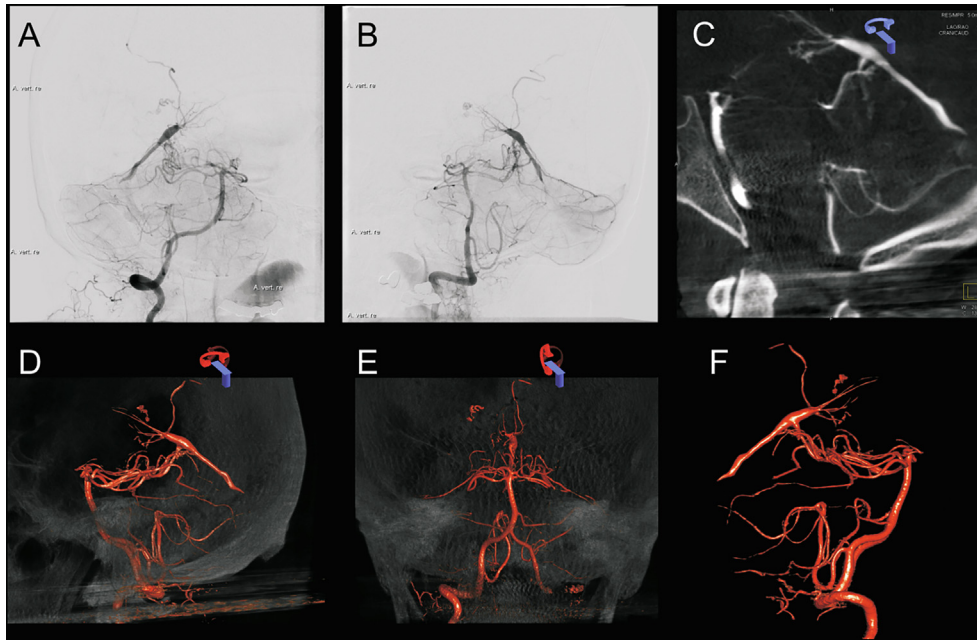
Angiography series prior treatment A, B: Angiography (C: CT angiography; D-F: 3-dimensional angiography;) reveals infratentorial dAVF with blood supply from the left superior cerebellar artery, draining to the straight sinus.
